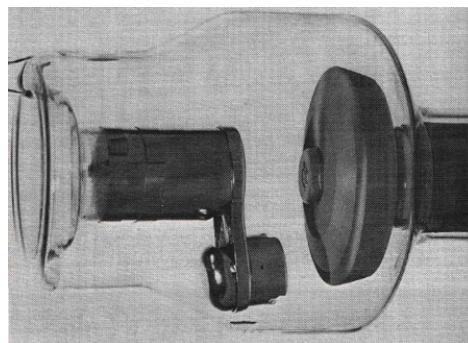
Rotational anode was first introduced in 1930 [1]. By rotating the anode, heat is distributed uniformly on the surface. This positively effects the X-ray beam quality device life expansion.
